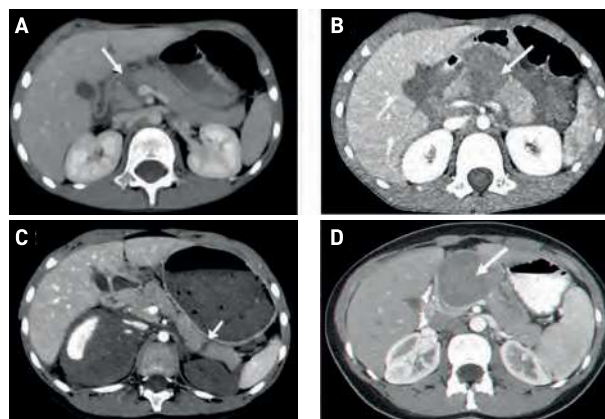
CT images showing [A] patient 1: pancreatic head transection, [B] patient 9: pancreatic body transection, [C] patient 8: pancreatic tail transection, and [D] patient 10: pancreatic mass
